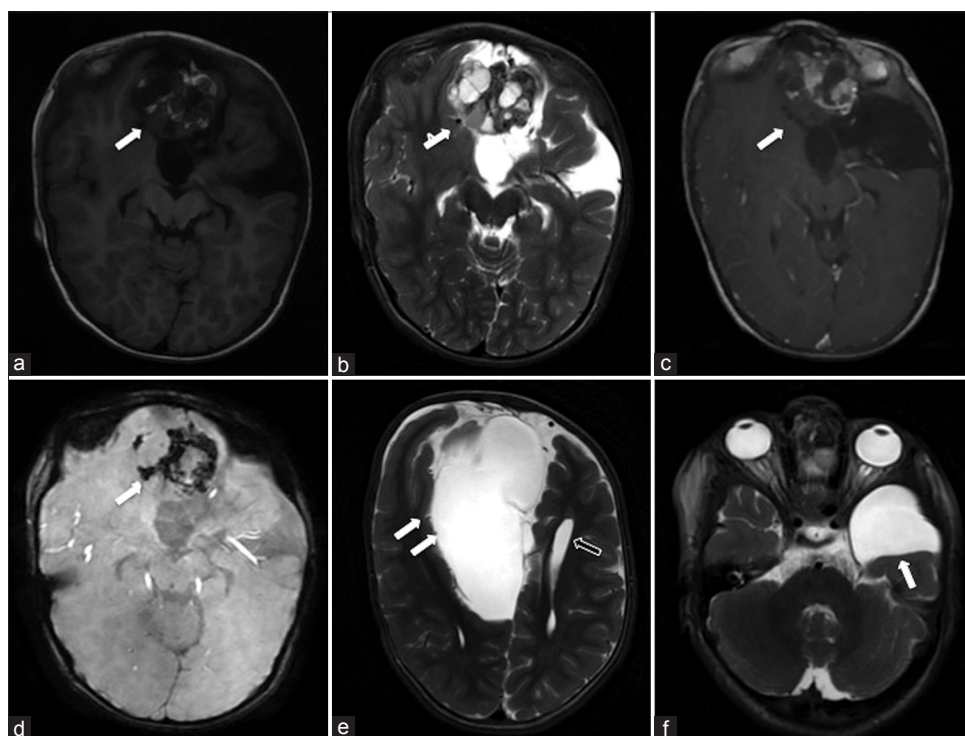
Axial T1W (a), T2W (b), T1WI post-contrast (c), and Susceptibility weighted images (d) show well-defined solid cystic lesion with T1 hyperintense and T2 hypointense components with hypointensity of SWI images. Enhancing soft-tissue signal intensity components also seen within. Axial T2WI (e) images of brain show parallel orientation of with midline sagittal sections suggestive of corpus callosal agenesis. A dorsal extra-axial CSF signal intensity cyst (solid white arrows in e) is seen along the falx cerebri communicating with third ventricle. Caudal axial T2WI sections (f) show a CSF signal intensity extra-axial arachnoid cyst (white arrow) in the left anterior temporal fossa causing mass effect over underlying anterior temporal lobe. T1W1: T1-weighted imaging, T2W2: T2-weighted imaging, SWI: Susceptibility-weighted imaging, and CSF: Cerebrospinal fluid.
